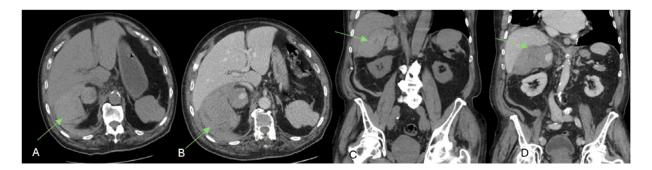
Abdominal and pelvic computed tomography (CT) scan of an 86-year-old gentleman in Case 1 (A) green arrow pointing towards the adrenal hemorrhage. The maximal size of the abnormality was 120 x 90 x 83 transverse, craniocaudal, and anteroposterior measurements respectively. (A) axial view of primary career organized CT KUB (Kidney, Ureter, and Bladder); Mean density of ovoid lesion; 59.7 Hounsfield Units (HU). (B) axial view of repeat CT AP with contrast enhancement, organized in Emergency. Ovoid density was identified again; Mean density 59.9 HU, with an area of hyperdensity on the medial side of ovoid mass; 116 HU. (C) coronal view of primary career organized CT KUB, HU as in (A). (D) coronal view of repeat CT AP with contrast enhancement organized in Emergency. HU as in (B).
